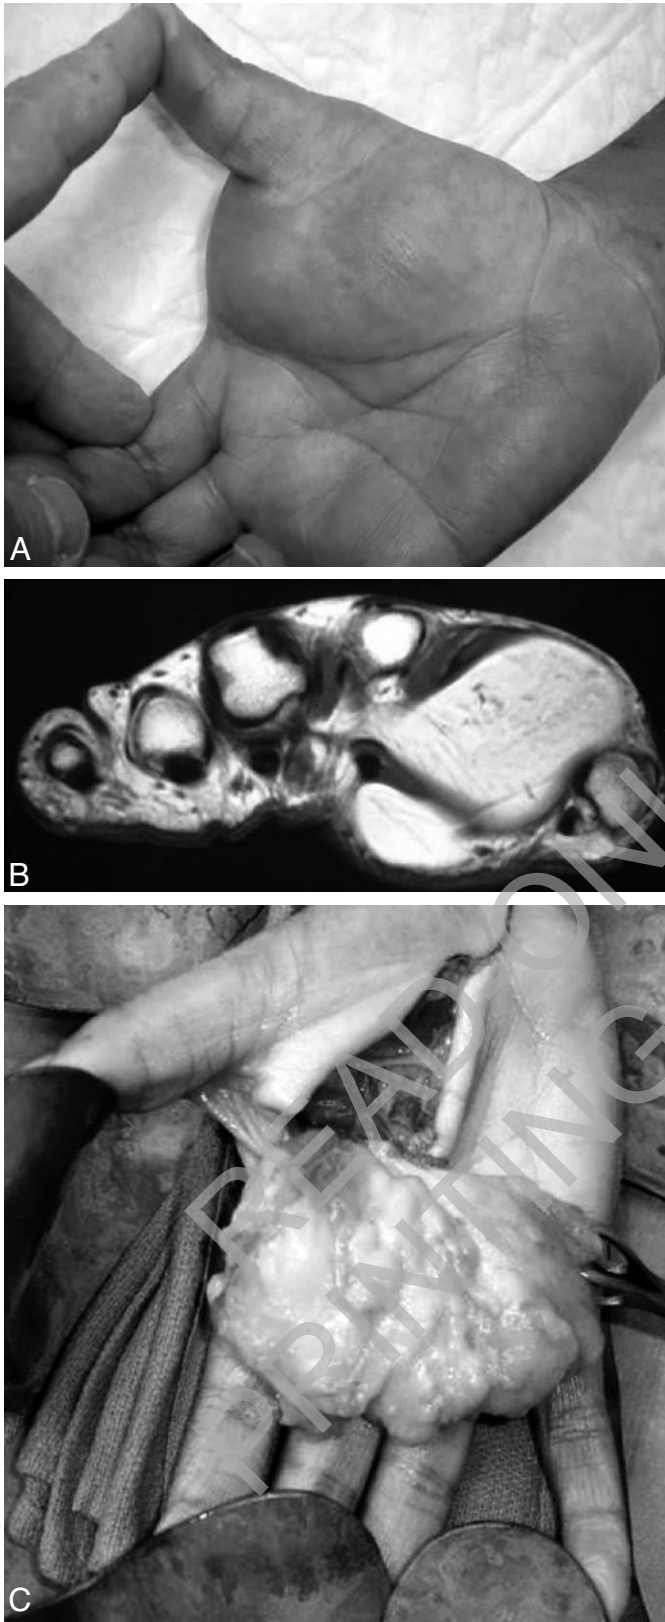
Benign lipoma, right hand. Preoperative photograph of the right hand showing moderate swelling of the thenar eminence (A). MRI of the right hand showing the homogenous appearance of a benign bilobulated lipoma located in the thenar eminence, transverse plane (B). Intraoperative photograph of the right hand showing the benign bilobulated lipoma dissected from the deep structures of the thenar eminence (C).
